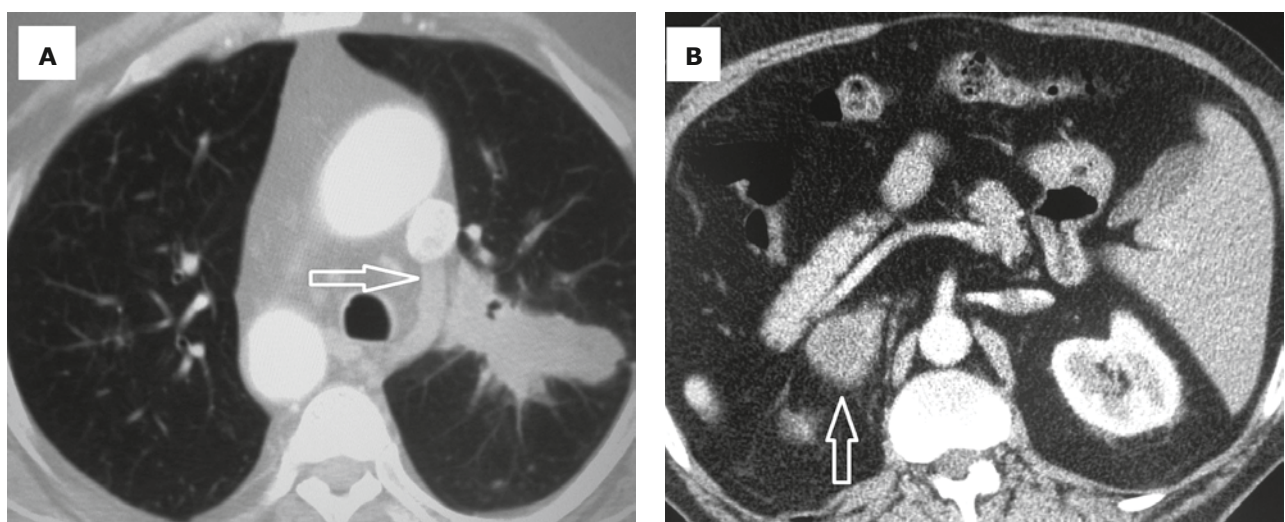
A. Left tracheobronchial angle involved by the tumor infiltration of the left lung. Left position of the azygos vein is marked (arrow). B. Abdominal computed tomography confirms the mirror image and enlarged right suprarenal gland (arrow)
